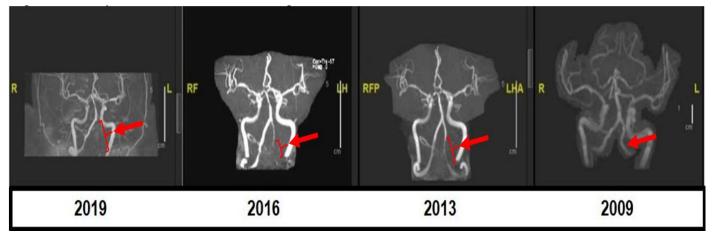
Sequence of MRI brain images
